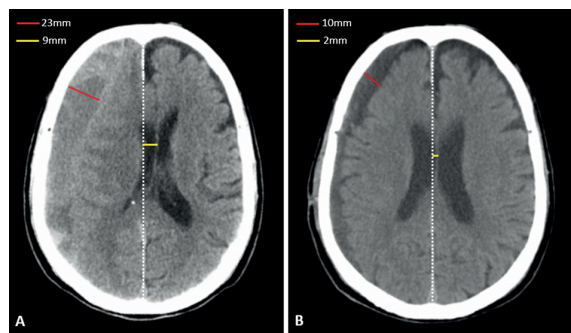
Non-contrast head computed tomography scans of a patient with chronic subdural hematoma on the right side (A) before treatment and (B) after treatment. Hematoma thickness and midline shift both decreased after the intervention.
